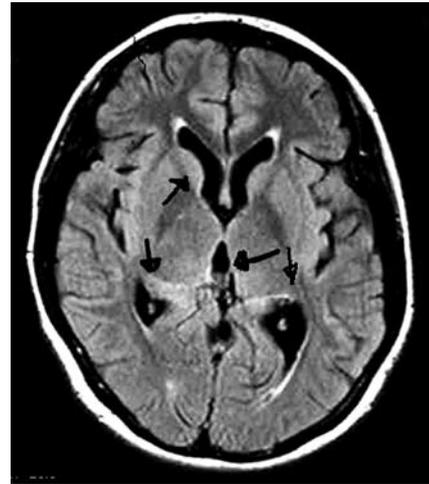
After initiation of urokinase therapy, MRI shows normal sized ventricular system.
